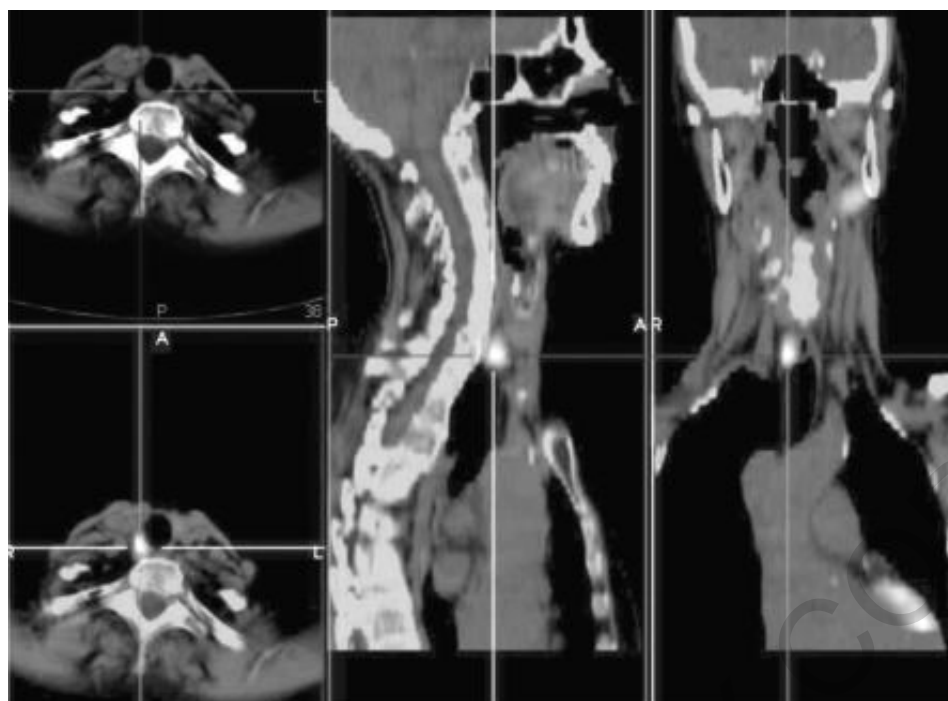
^{99m}Tc -MIBI, SPECT CT: right inferior parathyroid adenoma.
